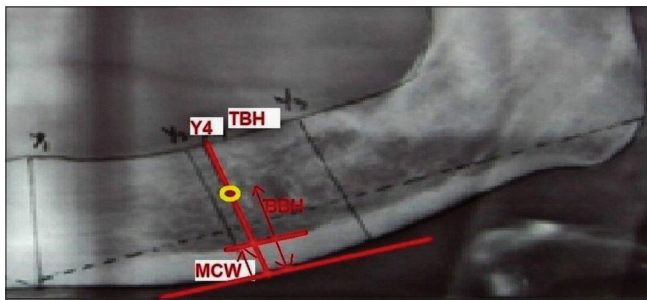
Assessment of PMI on the basis of MCW and BBH along with assessment of ABL based on radiographic TBH and BBH
